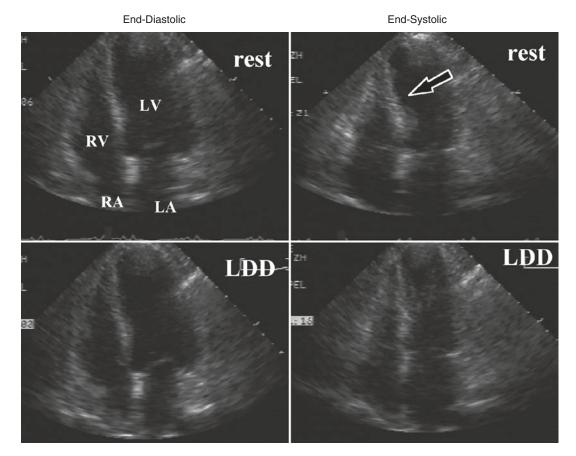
End diastolic and end systolic still frames of an apical four-chamber view at rest and during low-dose dobutamine infusion. Note the presence of myocardial
